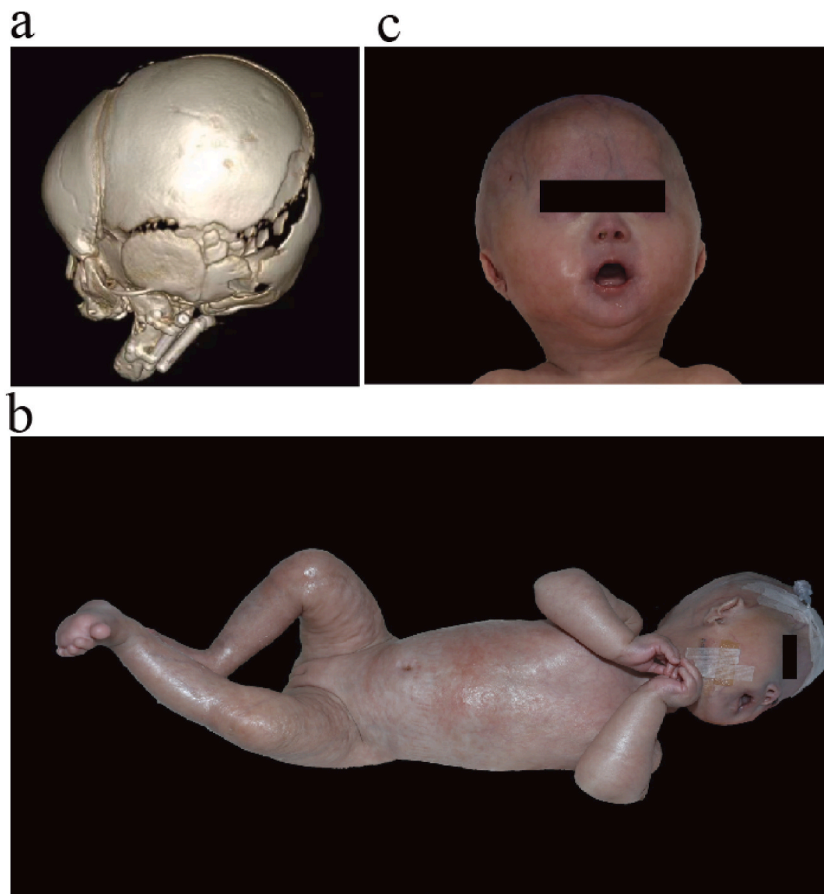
Computed tomography image and appearance of progeria of the patient. (a) Computed tomography image showed craniofacial disproportion and widened cranial suture of the patient. (b) The patient was noticed to have sclerotic skin, dry skin, lipoatrophy, and joint stiffness when she was at five months of age. (c) Manifestations of head and neck included prominent scalp veins, small ear lobes, hair loss, and craniofacial disproportion.
